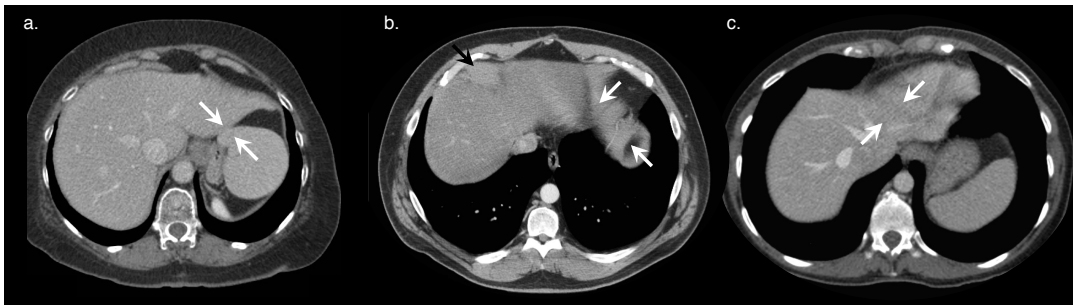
Imaging pitfalls which may limit liver segmentation on CT.
